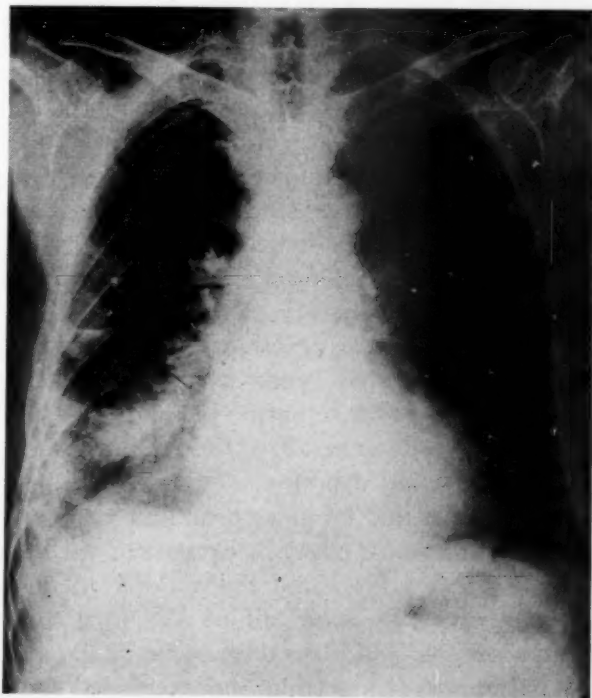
X-ray of chest, showing the following: the heart is slightly enlarged, and there are pleural scarring and small fluid accumulations on the right. Density in the lower right lung is due to pleural change.
